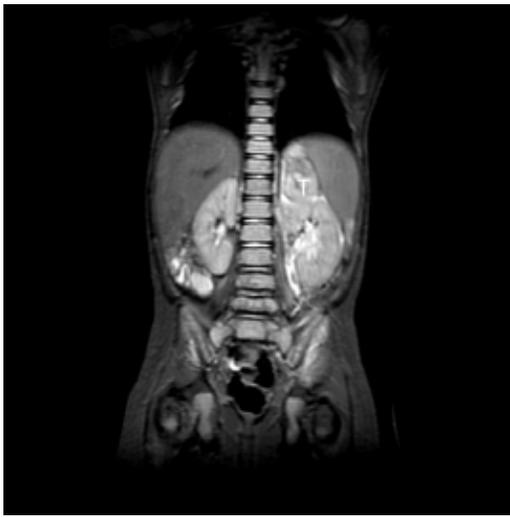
MRI showing left adrenal neuroblastoma marked "T".
